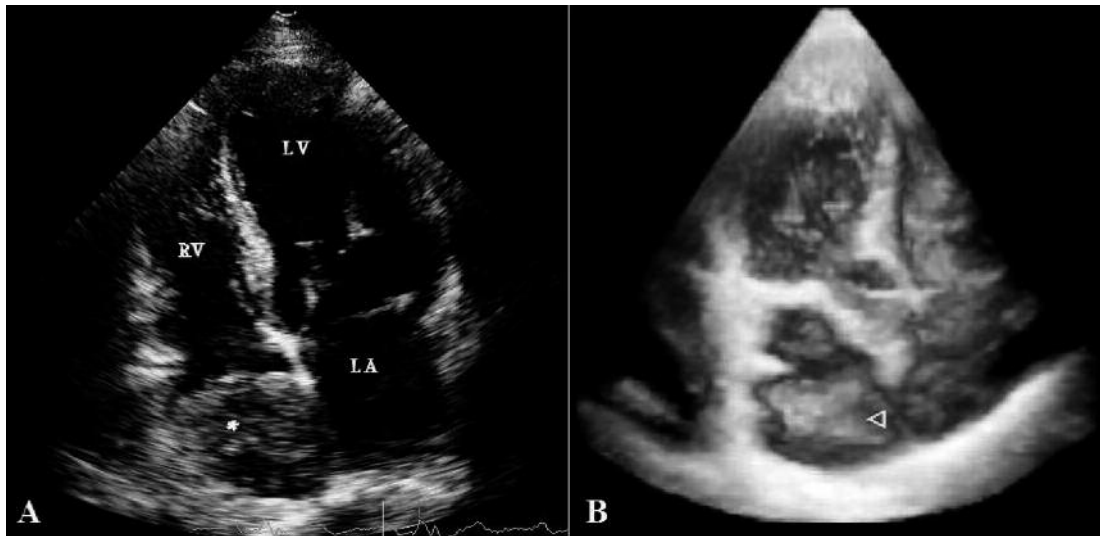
A, Four chamber Apical view (LV. Left Ventricle; LA. Left Atrium; RV. Right Ventricle; Asterisk. Right atrial mass). B, Real-time three-dimensional echocardiography (Arrow Head. The mass in the right atrium).
